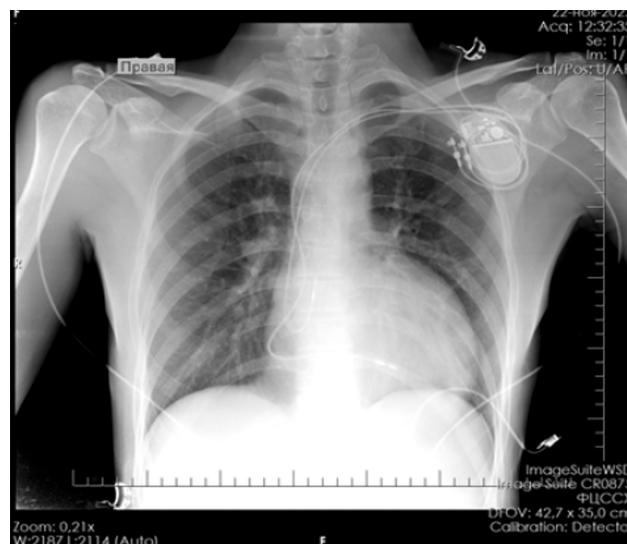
Patient's X-ray.
